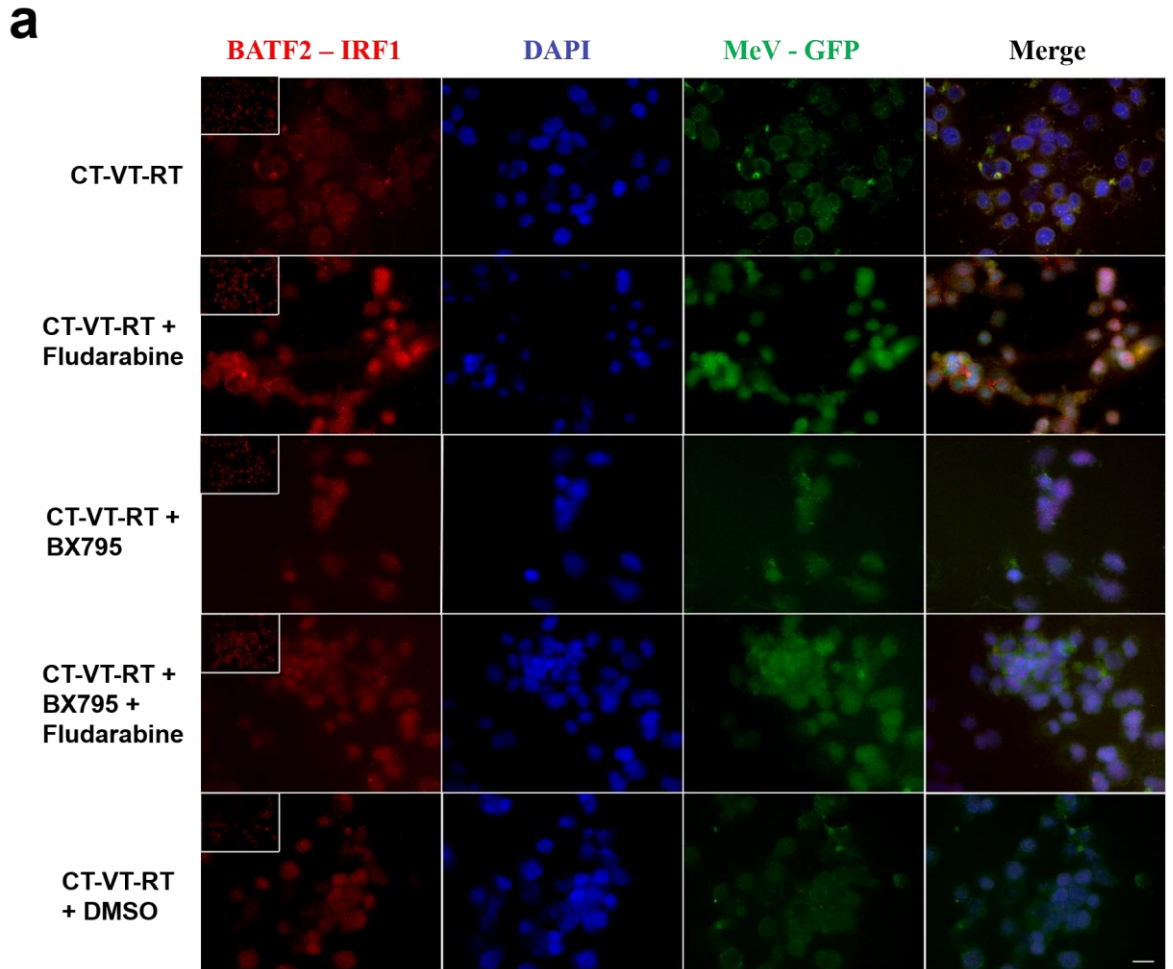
BATF2 interacts with IRF1 in the absence of IFN- β -STAT1 signalling. a, Proximity ligation assay reveals potential interaction of BATF2 with IRF1 observed through red amplification signal with highest intensity in cells treated with CT-VT-RT + fludarabine while basal signal was observed in CT-VT-RT and CT-VT-RT + DMSO alongside IgGs (Inset). b, Caspase 3/7 activity assay in CT-VT-RT
